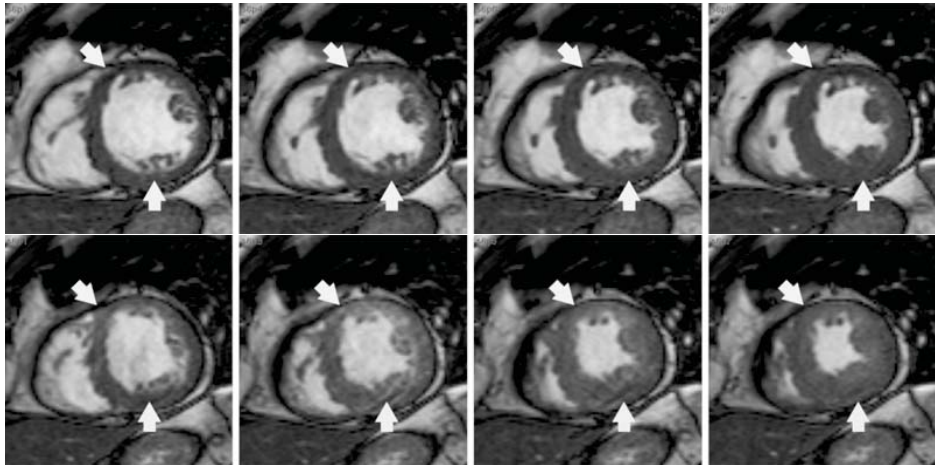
Resting (TOP) and dobutamine stress (BOTTOM) cine-MR images from the same patient at a single MR acquisition session. An increase of dobutamine-induced wall thickening is visible at the inferior region (the bottom arrows). This indicates a possible viable myocardium. At the anterosseptal region (the top arrows), there is no increase of LV function from rest to stress, which suggests non-viable tissue.
